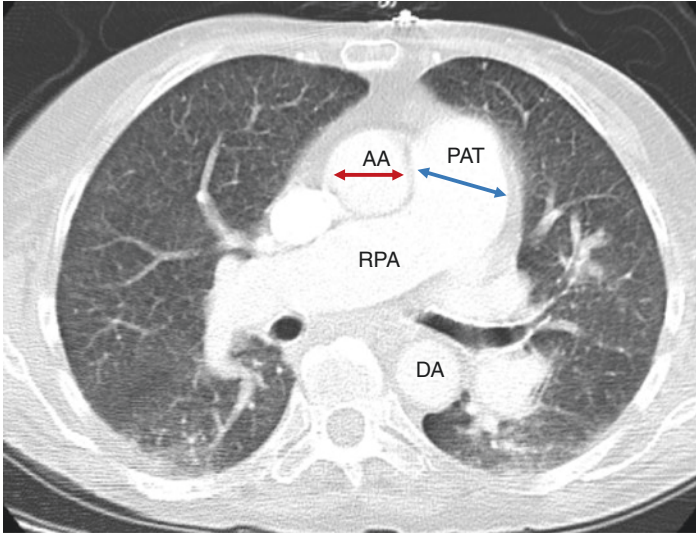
Features of pulmonary hypertension on contrast CT scan of the chest. Enlarged pulmonary arterial trunk (PAT) is larger than that of the ascending aorta (AA) at the same level. Right pulmonary artery (RPA) is also dilated. Descending aorta (DA) also shown
